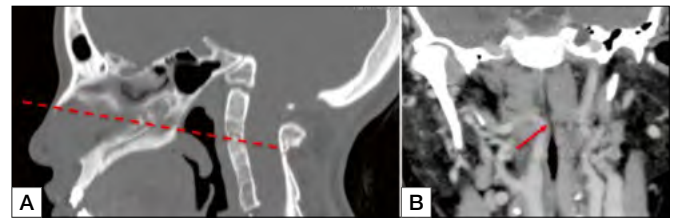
Importance of accurate preoperative radiological evaluation in order to choose the best corridor of approach. (A) CT scan of children with impression basilaris in which we preferred a transnasal corridor. (B) Angio CT showing an internal carotid kinking in the pharyngeal wall that exclude the anterior route to the CVJ.
